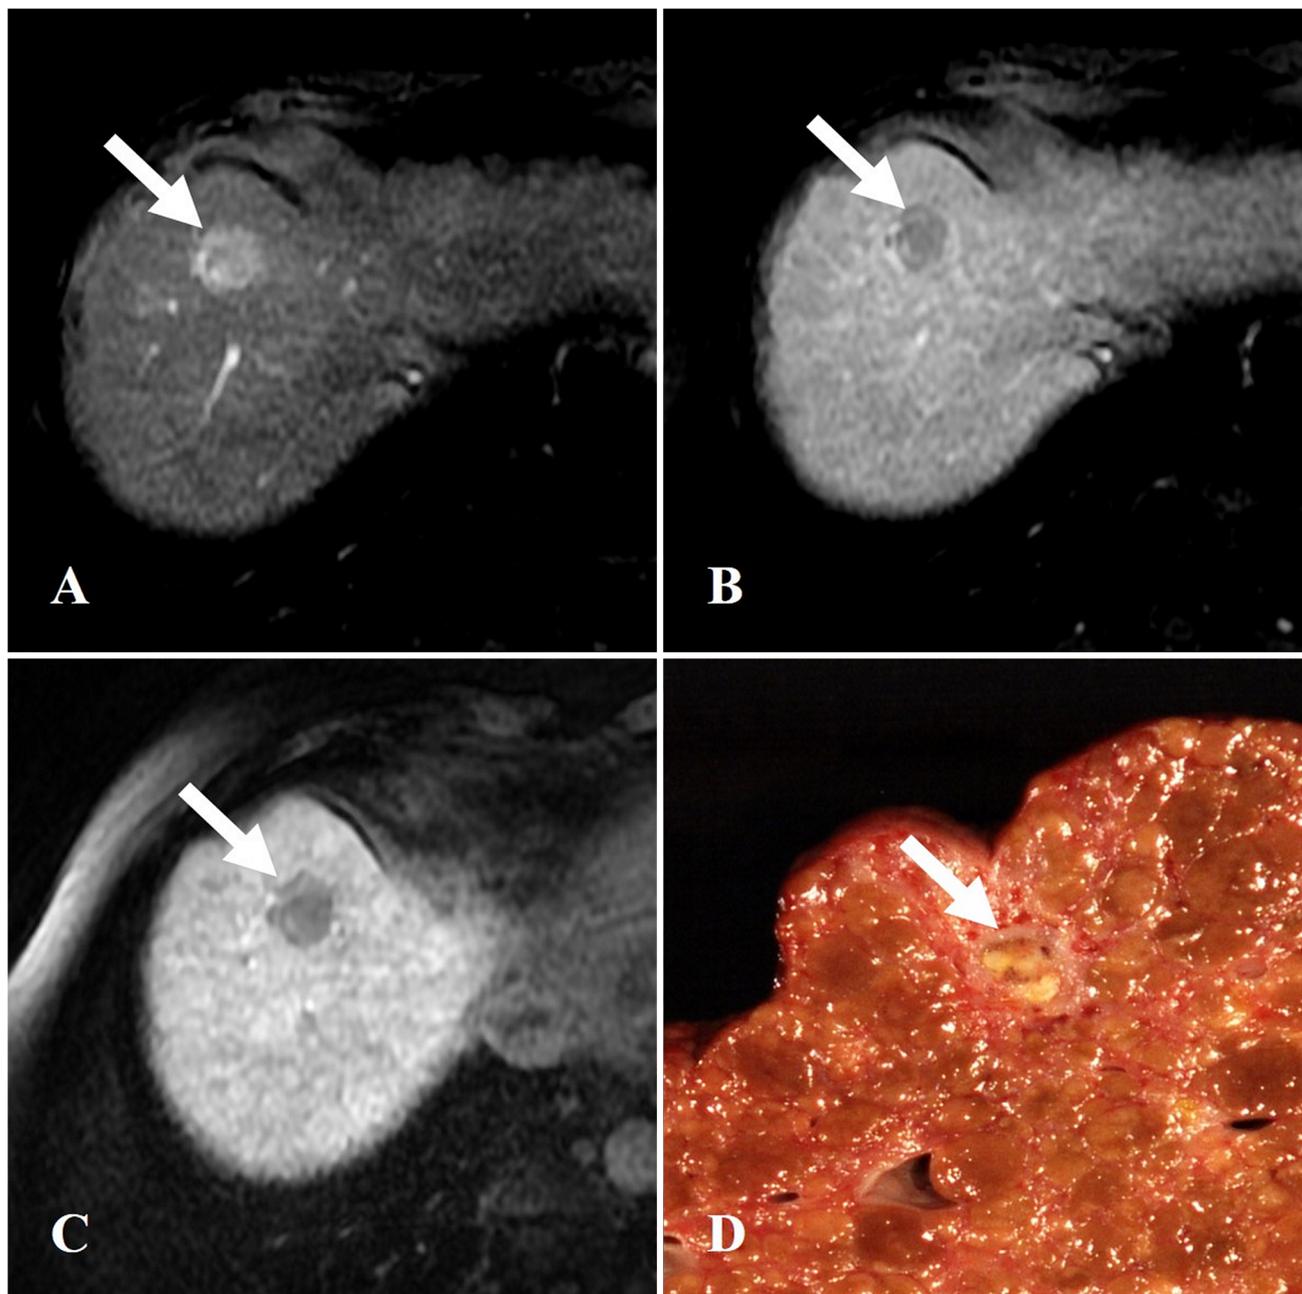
69-year-old female with history of NASH cirrhosis. On gadoxetate-MRI there is a 2.2 cm APHE observation on HAP (a) with “washout” on PVP (b) and hypointensity on HBP
